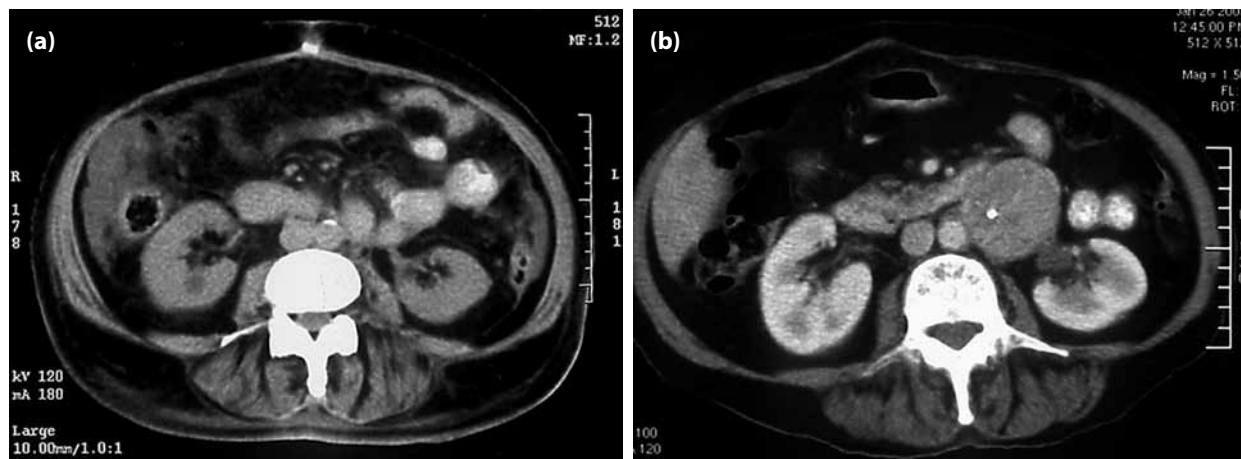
(a, b) Abdomen CT imaging before surgery.
